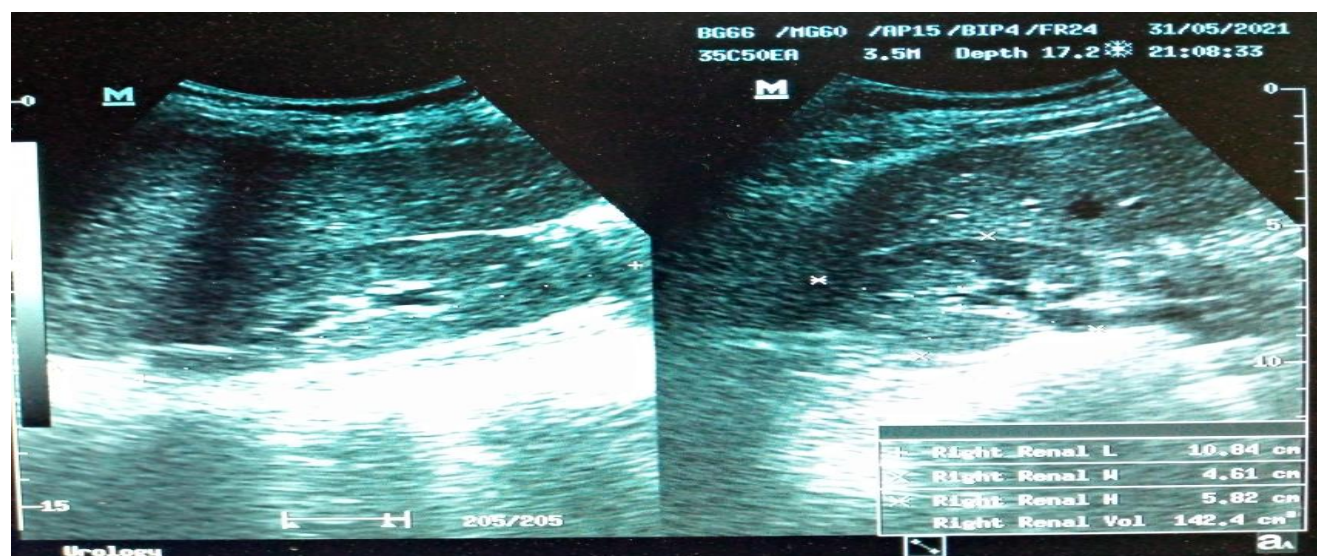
Shows sonogram of the right renal dimensions from both longitudinal and transverse plane.
